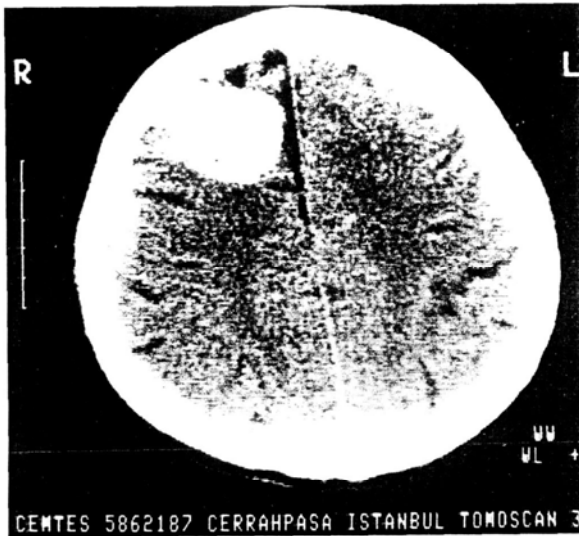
Nonenhanced CT confirms the right frontal hyperdense lesion without any discernible mass effect
